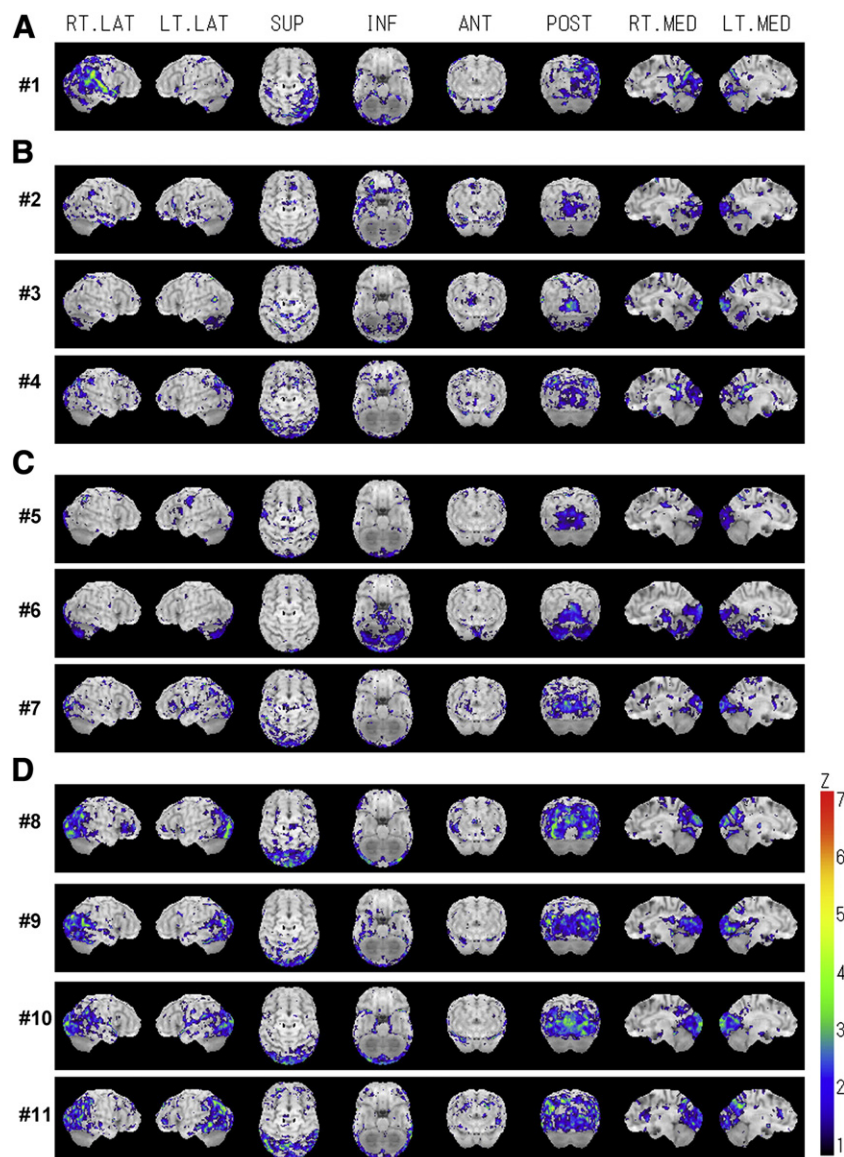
[^{18}F]-Fluoro-D-glucose positron emission tomographic (^{18}F -FDG PET) scan results in non-demented patients with glucose hypometabolism in the primary visual cortex at baseline.
